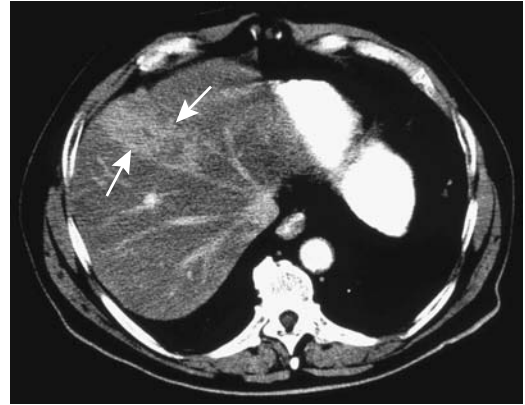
Hepatocellular carcinoma. Contrast-enhanced CT identifies a tumor replacing part of the right lobe (arrows). (Courtesy of Patrick Fultz, M.D., University of Rochester.)
